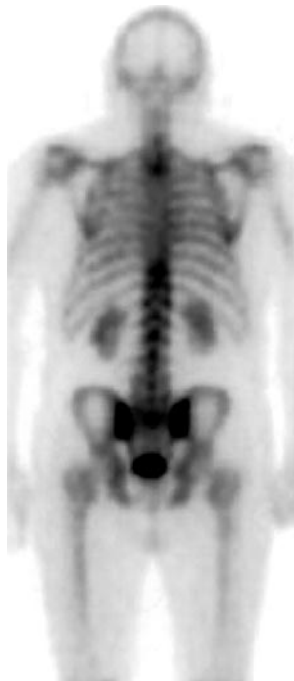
(a) Posterior planar scintigram shows bilateral foci of increased activity in a lower lumbar vertebra. (b–d) Transaxial (b), coronal (c), and sagittal (d) tomograms help confirm that this increased activity is confined to the posterior elements, sparing the pedicles, and therefore does not represent metastatic disease.
